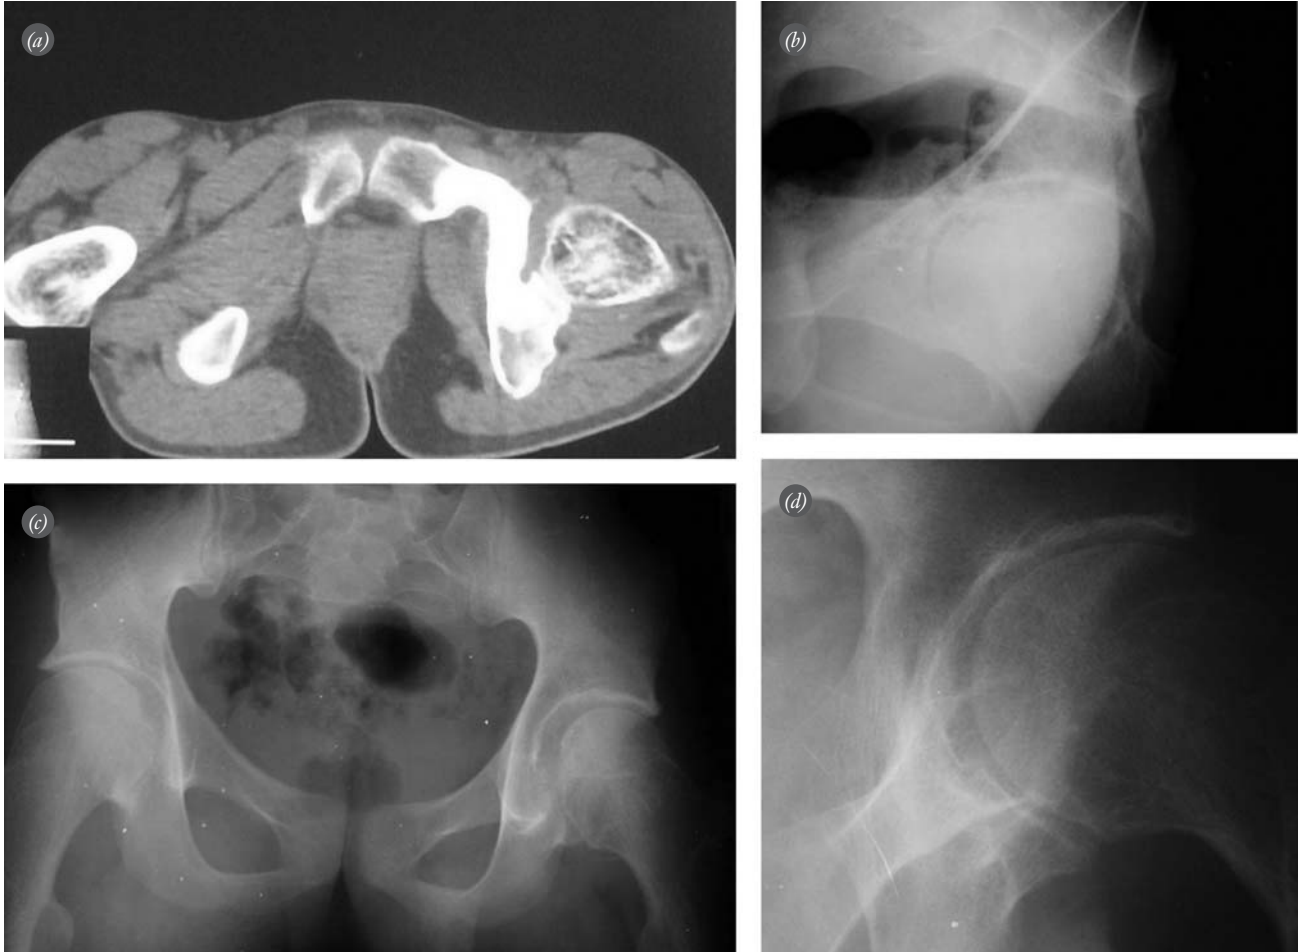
(a) Axial CT image demonstrates excellent femoral head remodeling without any evidence of recurrence of the tumor after ten years. (b-d) Last pelvic X-rays of the case demonstrate femoral head remodeling and a normal hip joint space.
